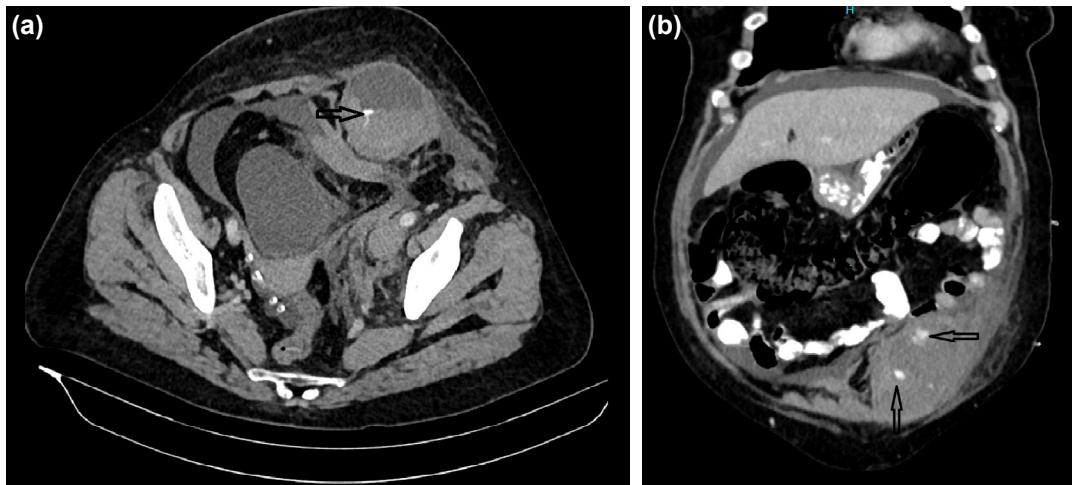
(a) Axial and (b) sagittal maximum intensity projection images of contrast-enhanced computed tomography showing left rectus sheath haematoma with fluid-fluid levels and active contrast extravasation (black arrows).
